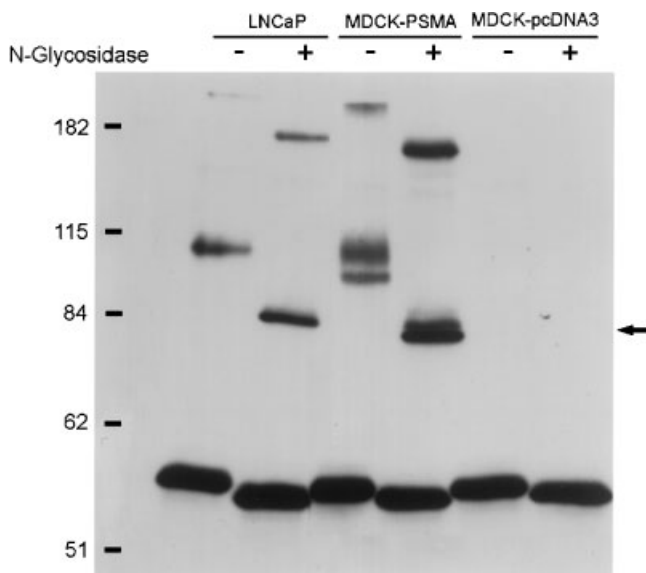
PSMA expression in LNCaP and MDCK cells. PSMA was immunoprecipitated from LNCaP or MDCK cells using mAb J59I. The precipitated samples were treated for 4 hr at 37°C in the presence or absence of N-glycosidase. Western blot analysis using mAb 7E11 reveals a glycoprotein of approximately 100 kDa and a core deglycosylated protein of approximately 84 kDa (arrow) in both LNCaP and MDCK-PSMA cells. No bands are recognized by 7E11 in untransfected MDCK cells. High molecular mass (200 kDa) appears to be a dimer of PSMA.
